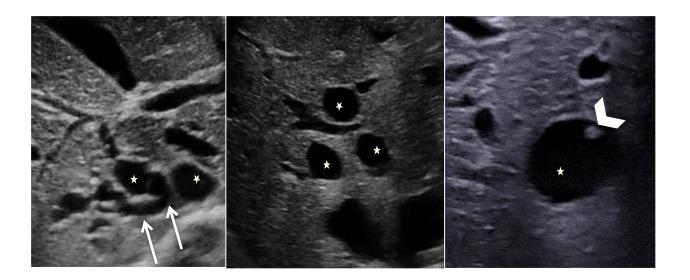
Caroli syndrome in a 7-year-old female patient, at ultrasonography. Several round anechoic cysts (stars) with thin wall, increased through-transmission, connected to the dilated fusiform biliary tract (arrows), with some of them showing the highly specific "central dot-sign" (arrowhead).
